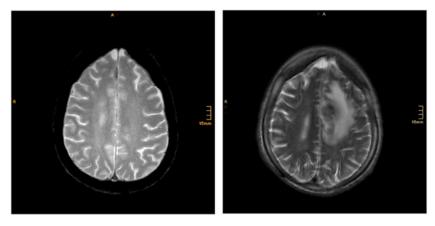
case 2: T2-weighted MRI scan from August 2020 (left) and upon presentation in November 2020 (right), the latter showing a ring-enhancing lesion in the left frontal cortex.
